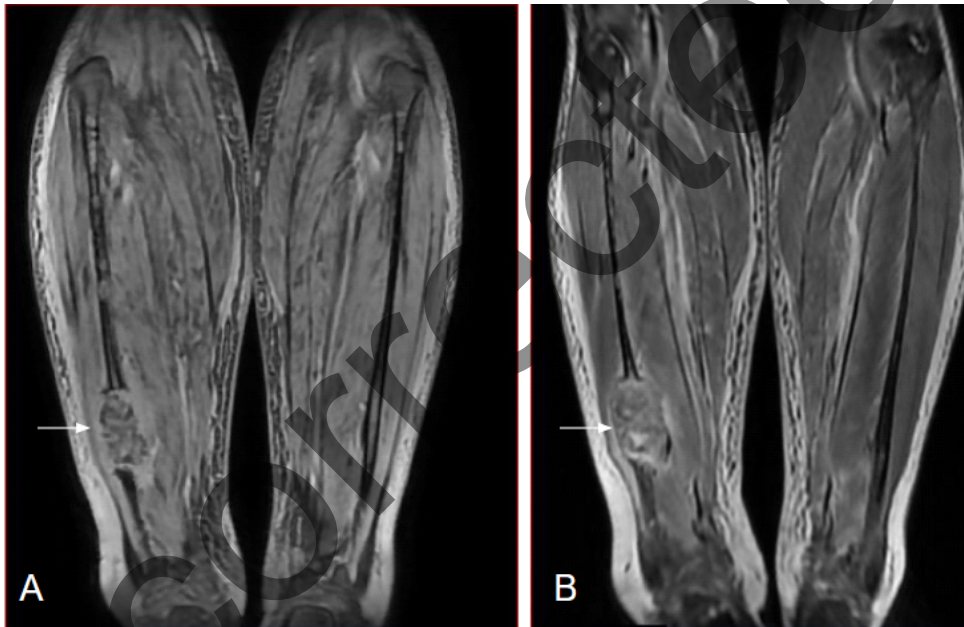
T1 weighted MRI (A) and T2 weighted MRI (B) images show expansile heterogeneous mass (arrows) in distal fibula with cortical breach and extension in surrounding soft tissue; features consistent with aggressive bone lesion which turned out to be myeloma.
